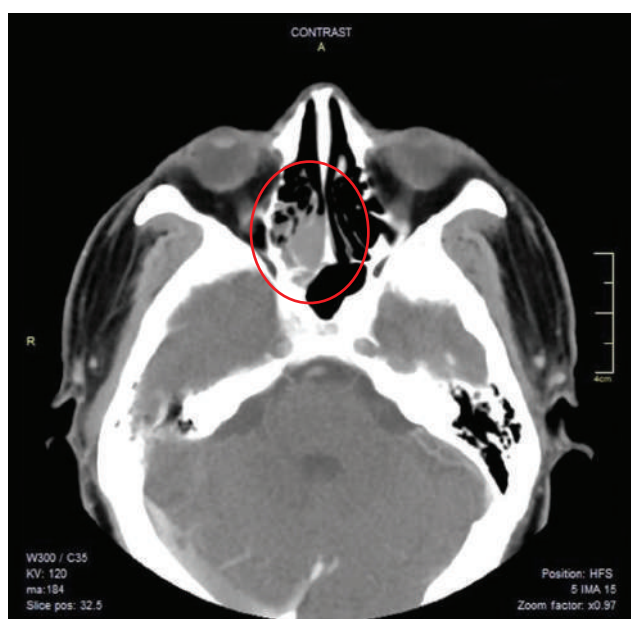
CT scan showed a 2.6 x 2.5 x 1.5 cm polypoid soft tissue mass in the right posterior nasal cavity extending into the posterior ethmoid sinus and into the right side of the sphenoid sinus.
